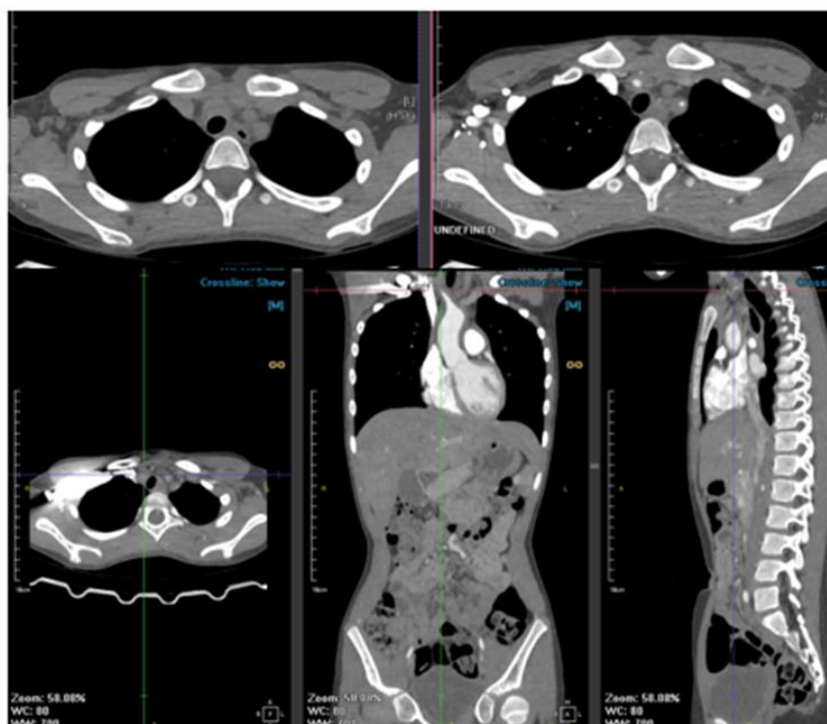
CT-scan Angiography Examination
